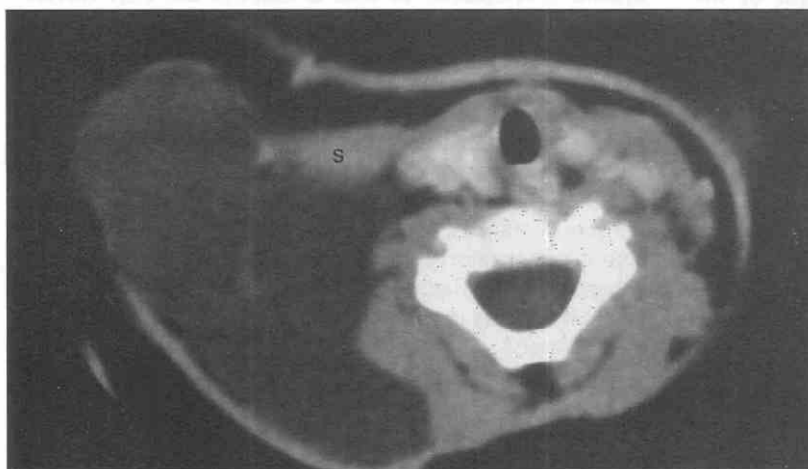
Cystic hygroma. Axial contrast-enhanced CT scan at the level of the first tracheal ring demonstrates a multilocular cystic mass without rim enhancement occupying the entire right posterior triangle extending toward the right axilla. S, Sternocleidomastoid muscle.
